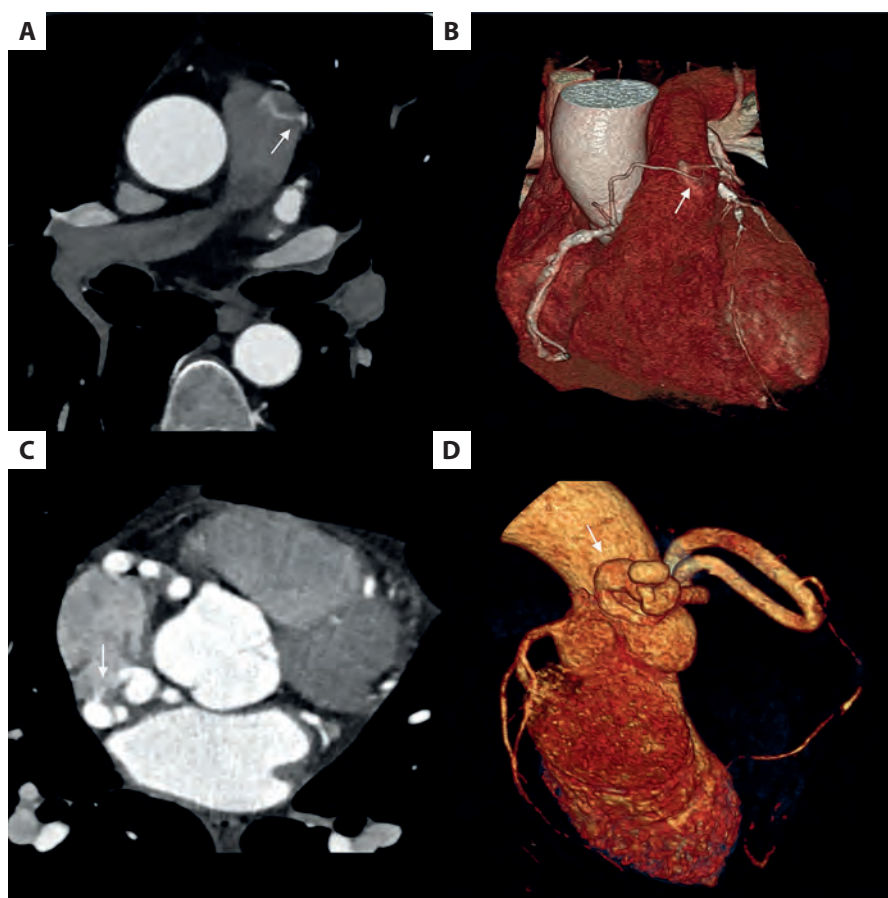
Coronary computed tomography (CT). A. Multiplanar reconstruction (MPR). B. volume-rendered reconstruction, the coronary artery fistula (CAF) between the right coronary artery (RCA) and the pulmonary artery (white arrows). C. MPR. D. volume-rendered reconstruction, CAF between the RCA and the superior vena cava (white arrows)
